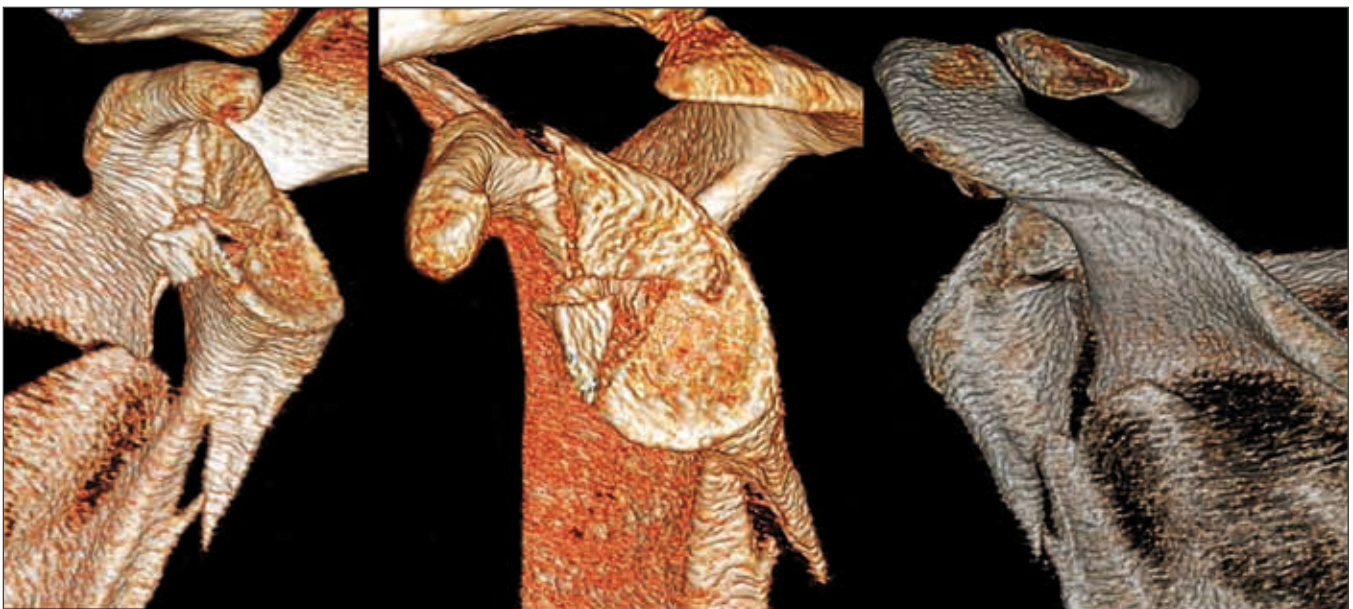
The fracture on 3D CT reconstructions.
